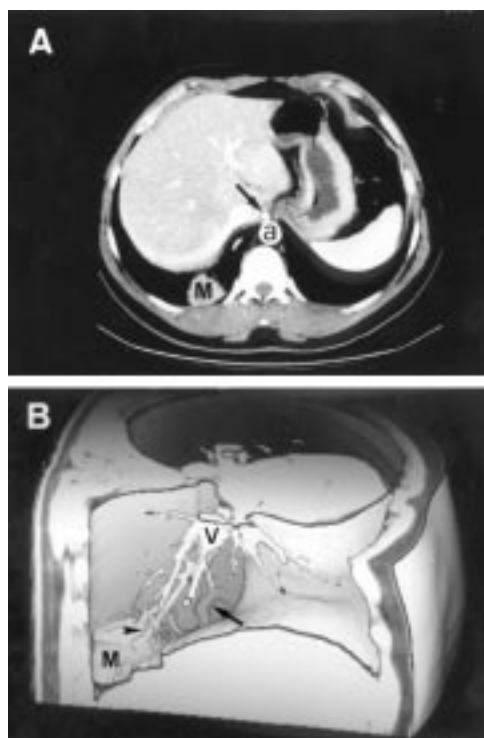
Spiral CT scan of case 2. (A) Contrast enhanced CT axial image showing the pulmonary mass (M) supplied by an anomalous systemic artery (arrow) arising from the upper abdominal aorta (a). (B) Right view of helical CT angiogram showing the course of the arterial vessel (arrow) to the pulmonary mass (M). Note the venous drainage (arrowhead) to the pulmonary veins (V).
